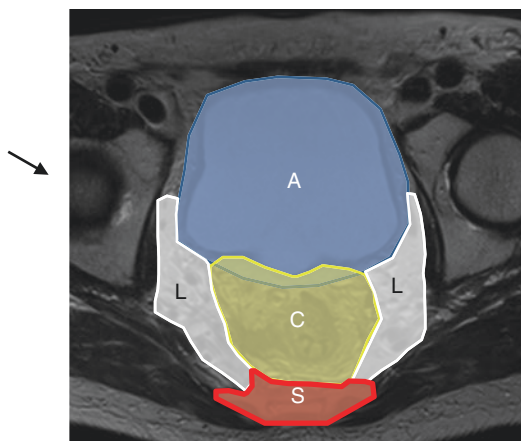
An axial MRI scan demonstrating pelvic compartments: A—anterior compartment including bladder in a male and bladder and uterus in a female; C—central compartment containing rectum and mesorectum; L—lateral pelvic sidewall containing branches of the internal iliac arteries, veins, associated nodes, ureters, and nerves; S—sacral compartment
